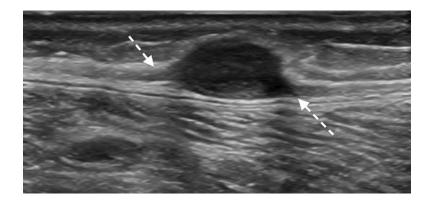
Schwannoma of the sural nerve on longitudinal ultrasound. Note "string sign" (*dashed arrows*) of the eccentric peripheral nerve entering and leaving the hypoechoic lesion
